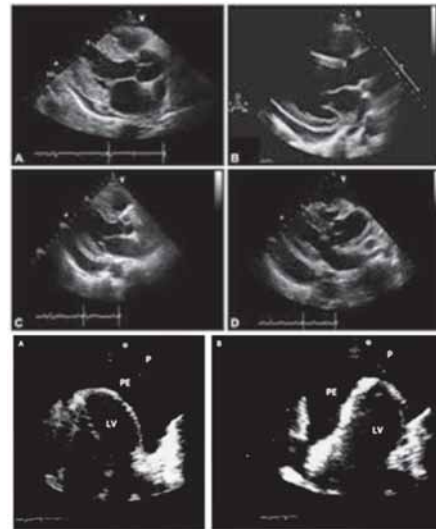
Echocardiogram demonstrated massive circumferential pericardial effusion with swinging motion of heart within large effusion.
